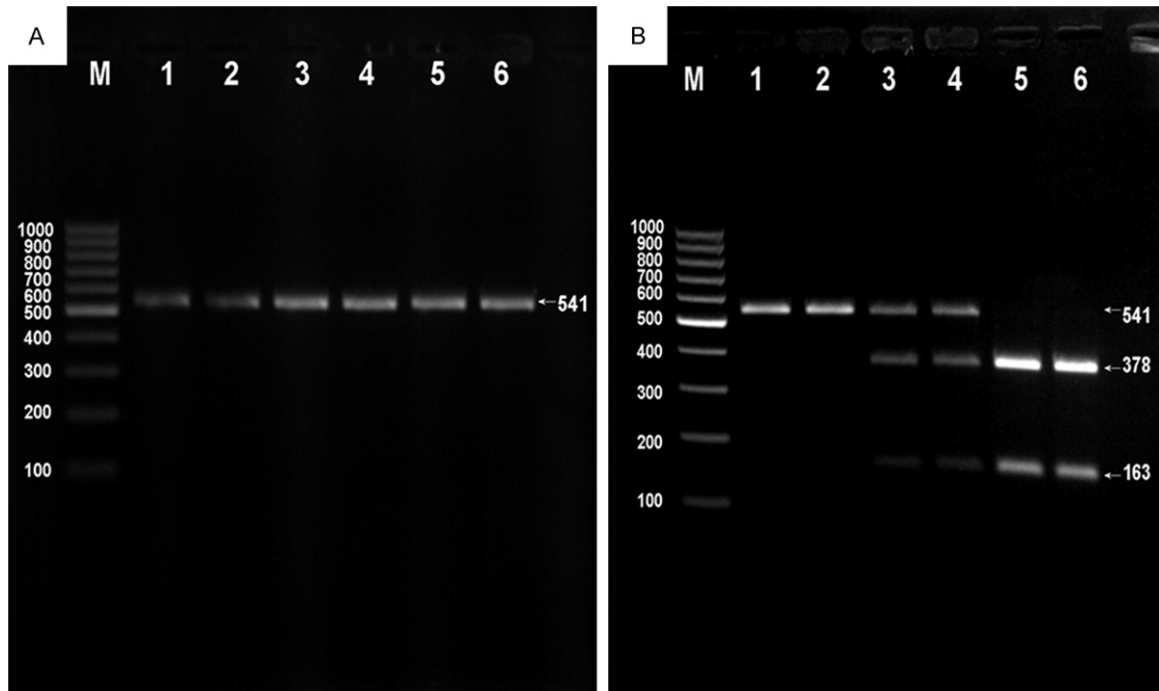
Electrophoresis of PCR products and genotyping of the *SPTY2D1* rs7934205 SNP. A. Lane M, 100 bp marker ladder; lanes 1-6, 541-bp band of PCR products. B. Lane M, 100 bp marker ladder; lanes 1 and 2, TT genotype (541-bp); lanes 3 and 4, CT genotype (541-, 378- and 163-bp); and lanes 5 and 6, CC genotype (378- and 163-bp).
